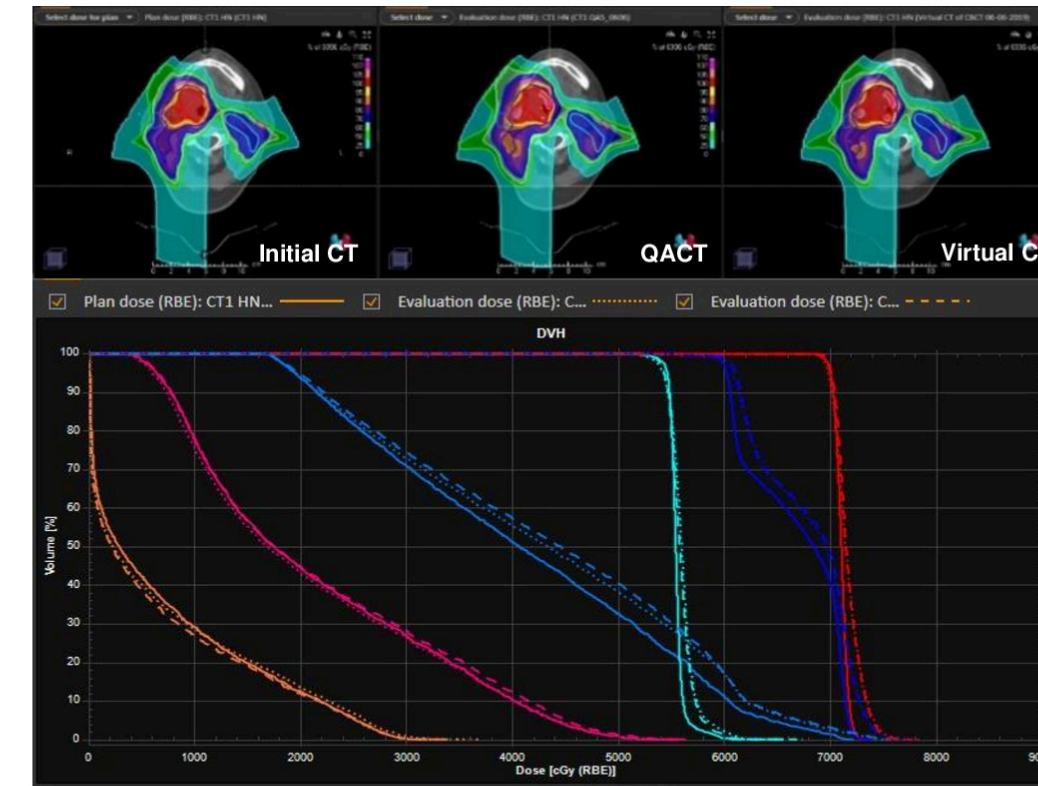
Dose distribution and dose volume histograms of a HN case that required ART. High agreement between the virtual-CT and reference QA-CT were observed. Solid line (planning CT), dotted line (QA-CT), dashed line (CBCT-based Virtual CT).
